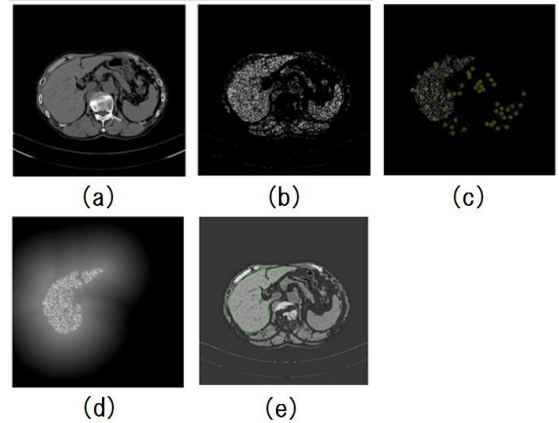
(a) A CT slice image, (b) Liver pixel candidates with narrow band classification, (c) Cluster center by the K-means method, (d) Probability image, (e) Liver contour by GAC.
